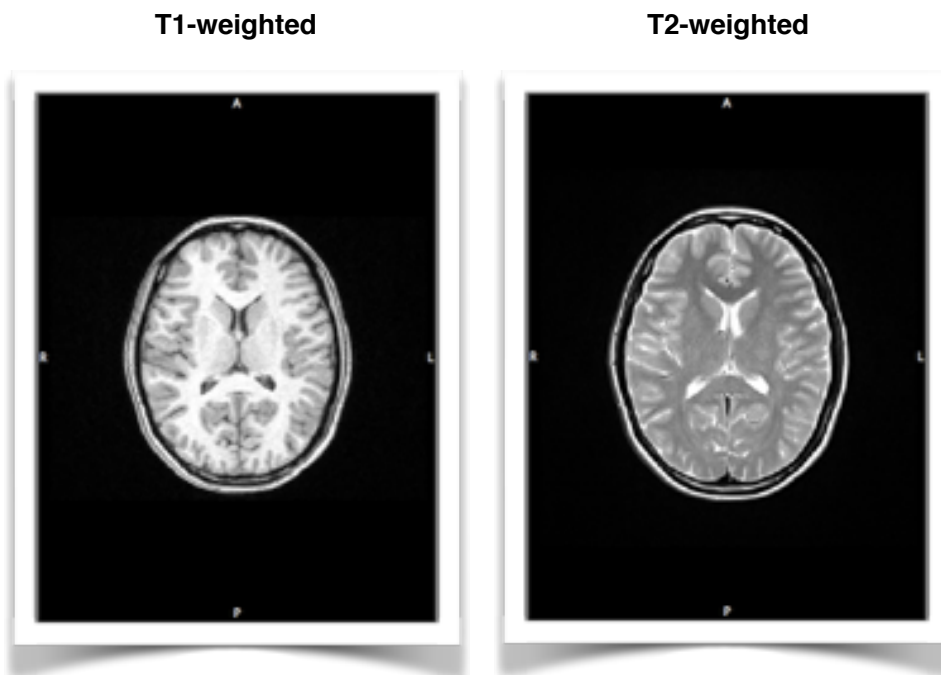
Examples of MRI brain scans in the axial plane: T1-weighted (left) and T2-weighted images (right).
